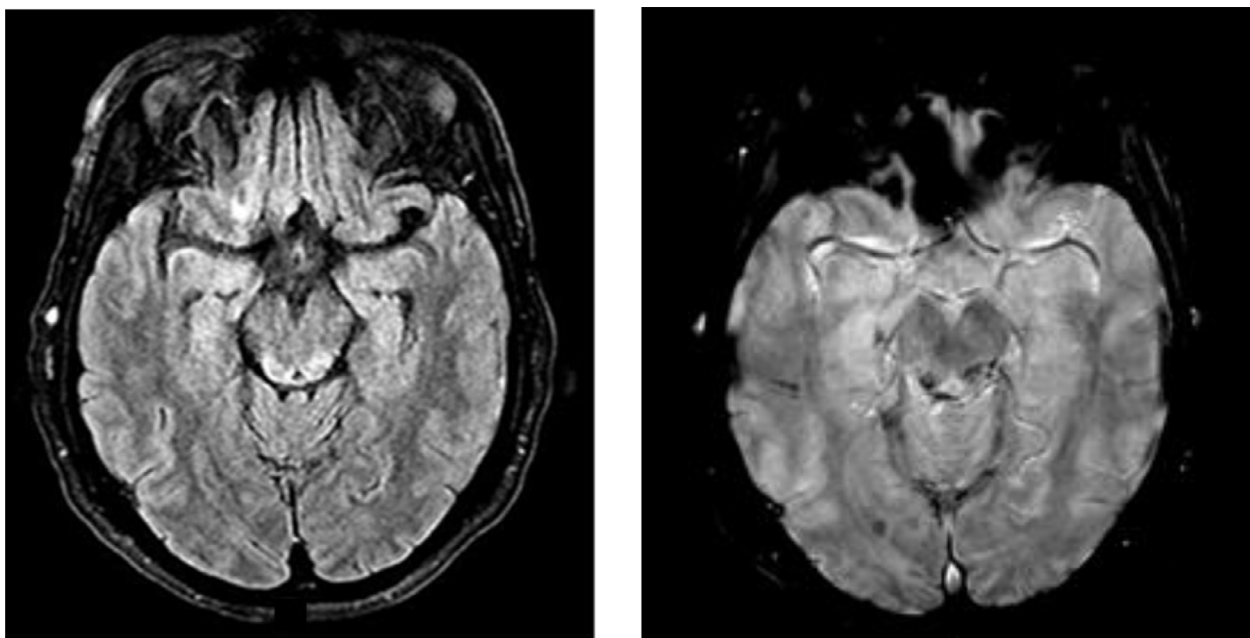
Axial FLAIR image reveals hyperintense signal in the dorsal aspect of the midbrain (left) with corresponding hemorrhagic component on the SWI (right).
